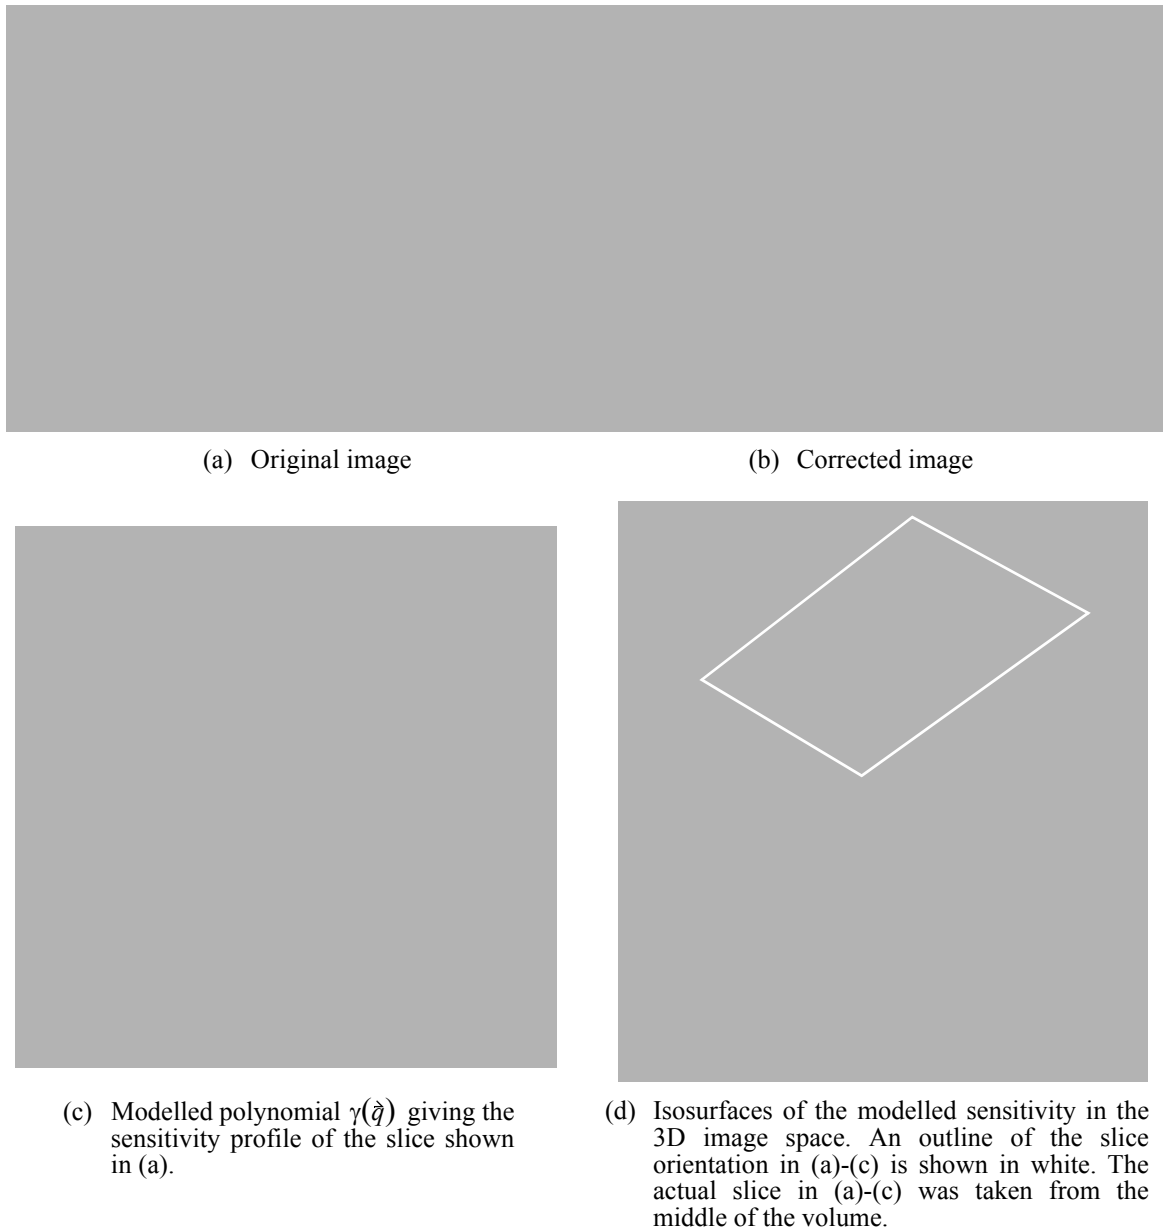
Sensitivity analysis of MR imaging using a knee coil.
